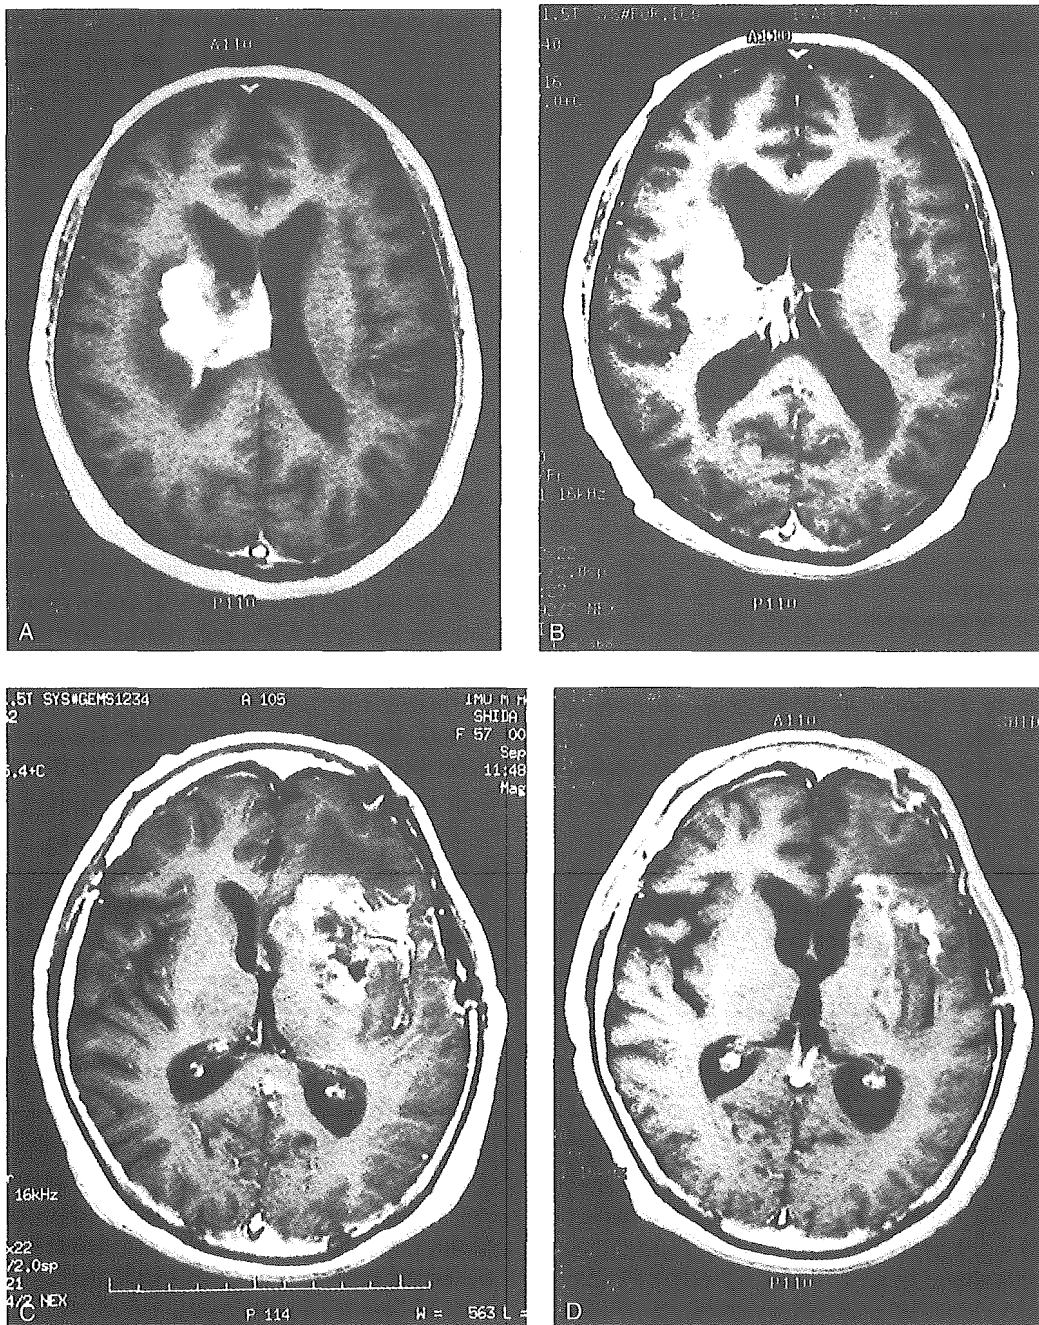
Gadolinium-enhanced T1 weighted MR images of patients showing a complete (A, B) and partial response (C, D). Before (A, C) and after HBO/IAR therapy (B, D). A and B, the patient of no. 16; C and D, the patient of no. 17 in Table 1.
